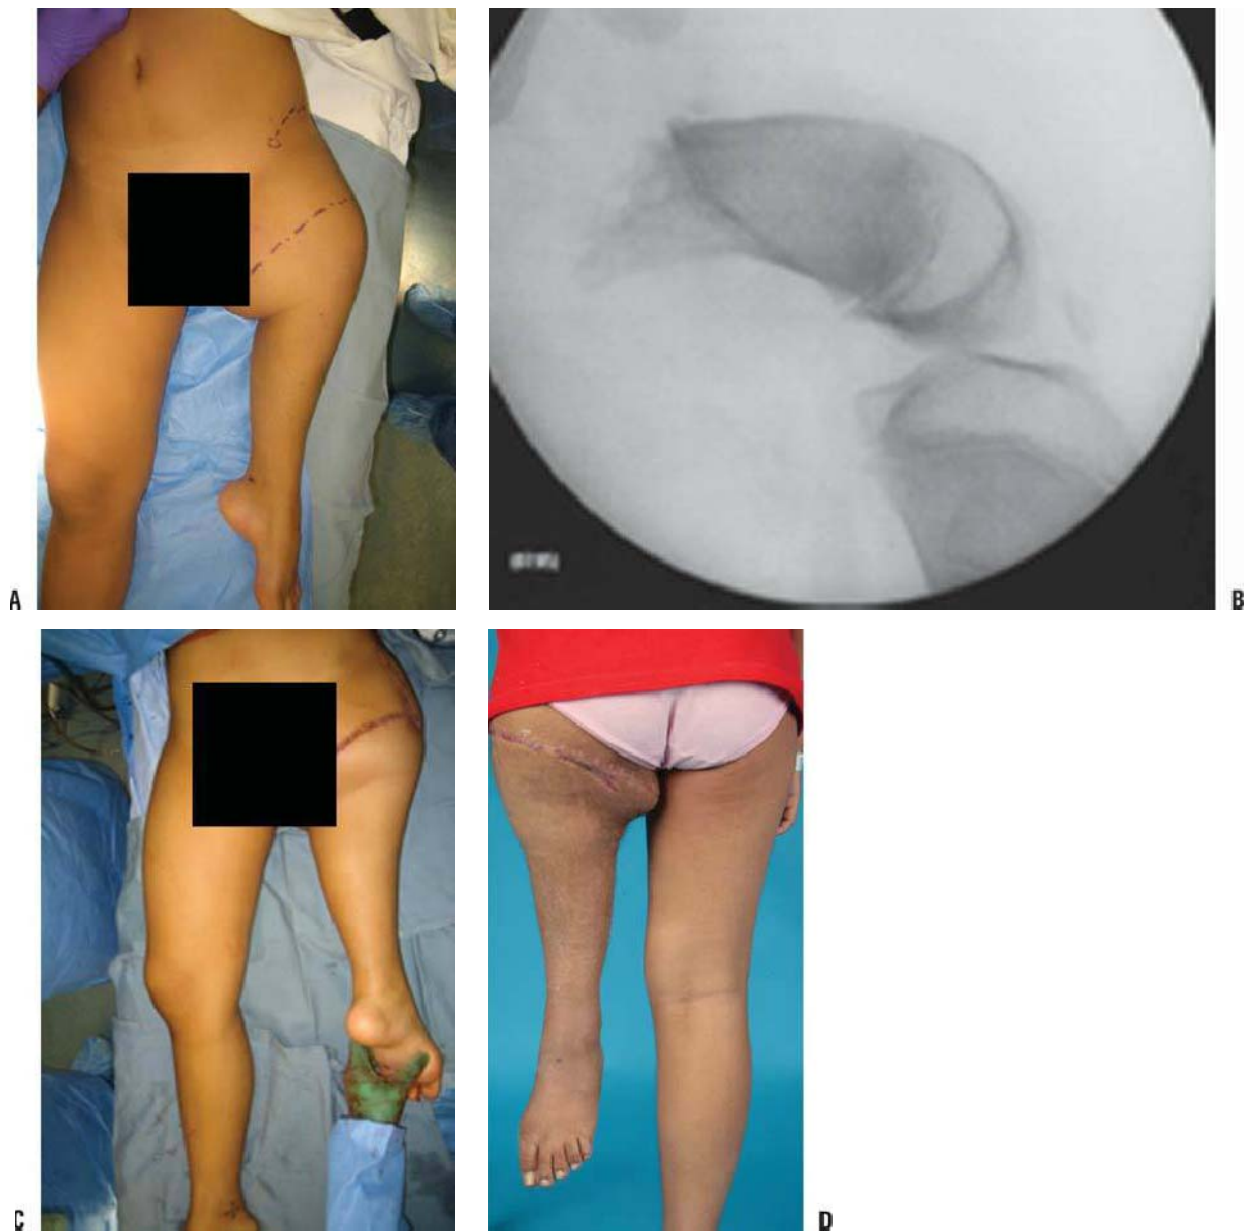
A: Preoperative clinical photograph of a patient with Gillespie type 2 PFFD. B: An intraoperative fluoroscopic radiograph demonstrating the extreme shortening of the femoral segment and lack of any acetabular development. C: Postoperative clinical photograph after Van Nes rotationplasty. D: Postoperative standing clinical photograph at 1 year of follow-up.
